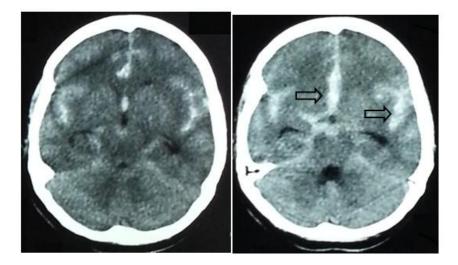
A 39 years old woman had severe bursting headache 'never before in her life' and followed by loss of consciousness. Her axial CT scan showing extensive subarachnoid hemorrhage involving all cisterns, bilateral sylvian fissure and frontal interhemispheric fissure.
